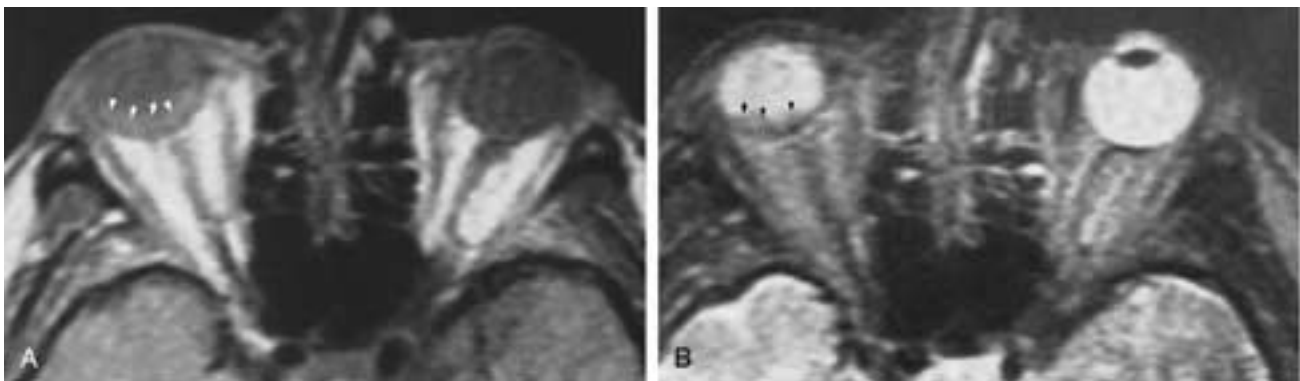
Choroidal metastasis. A, Axial PW MR image shows a hyperintense lesion (arrows) consistent with an ophthalmoscopic finding of choroidal metastasis. Note the irregularity of the lesion's surface. B, The lesion remained slightly hyperintense in this axial T2-weighted MR image.
